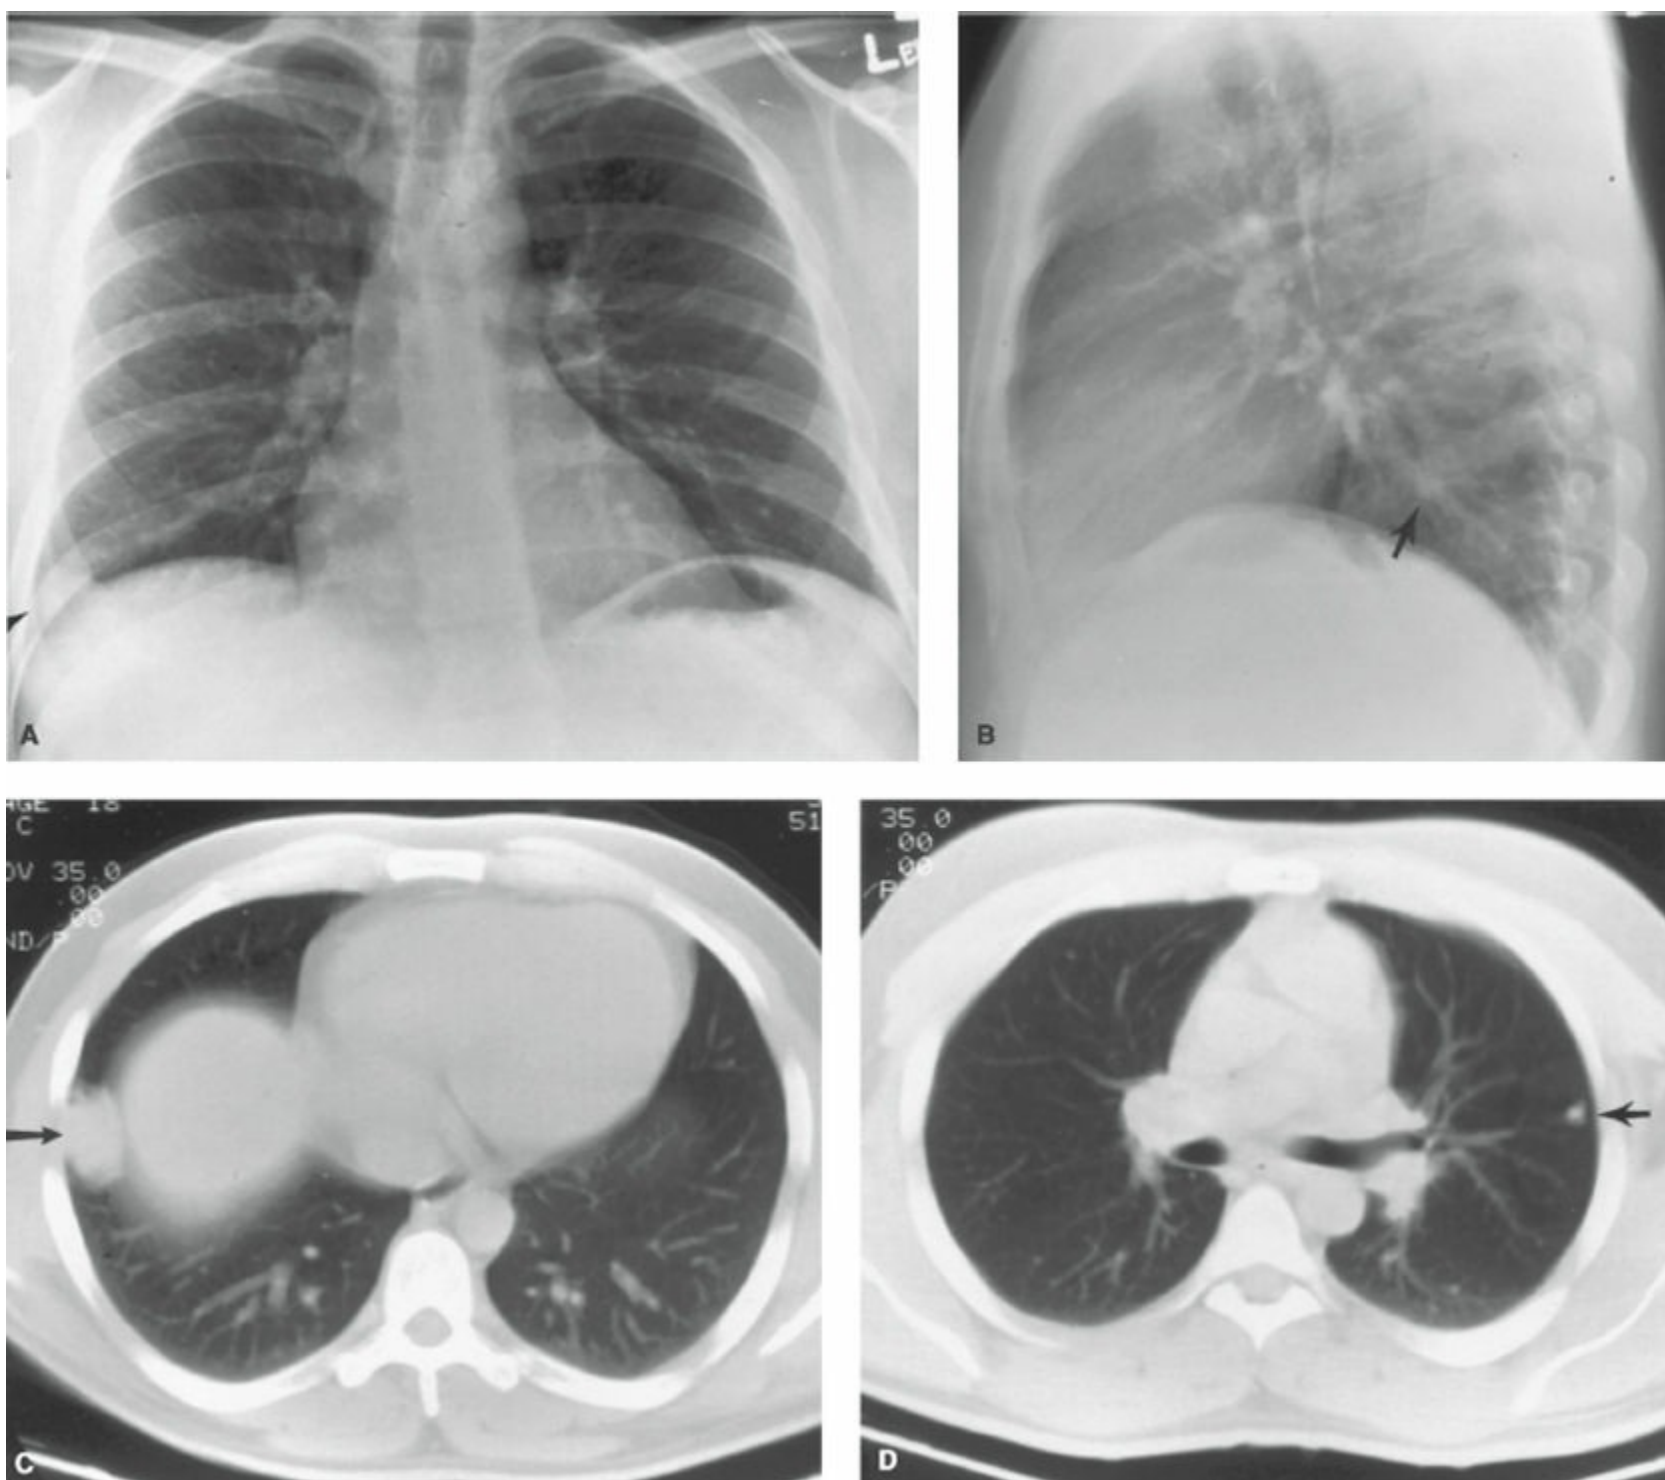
Imaging studies from a patient with metastatic embryonal rhabdomyosarcoma. Chest radiographs show a mass in the right lower lobe (*arrow*, A) that is best seen on the lateral view (*arrow*, B). Computed tomography (CT) confirmed the presence of this mass (*arrow*, C) and showed an additional nodule in the left upper lobe (*arrow*, D). At surgical exploration, however, multiple bilateral pulmonary metastases were found that measured less than 5 mm and therefore were not seen on CT.
